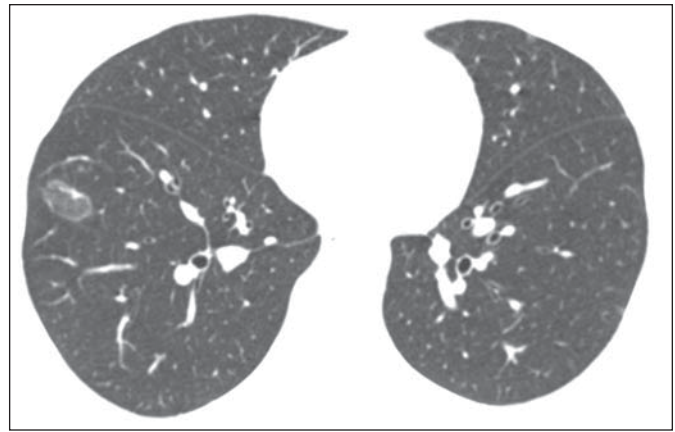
36-year-old woman with cryptogenic organizing pneumonia. High-resolution CT scan of lower pulmonary regions shows localized oval area containing central homogeneous ground-glass opacities and smooth ring of consolidation (reversed halo sign) in right lower lobe. Again, note absence of nodules.
